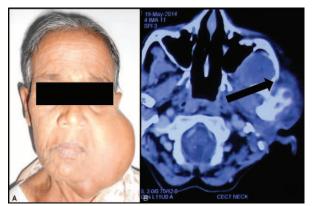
A, Clinical presentation of the ameloblastoma. B, Pathological fracture of the zygomatic arch on axial section of the CT scan.
